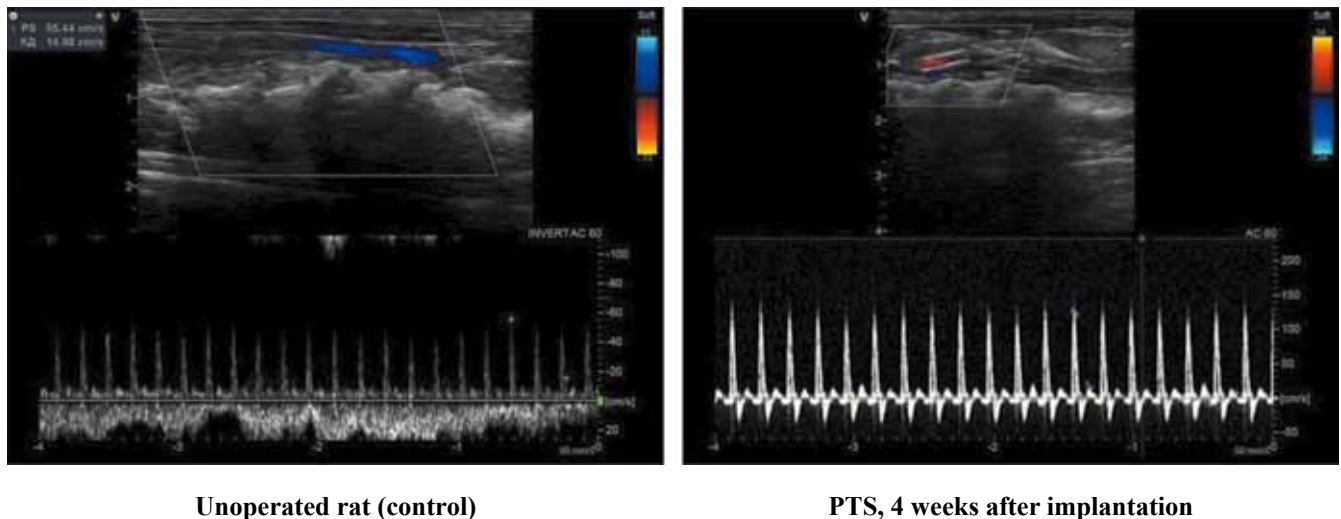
Doppler ultrasound of implanted coated PTS 4 weeks after implantation (typical measurement)
